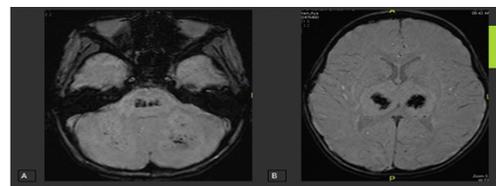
Axial Susceptibility weighted images (SWI) MRI of the brain at the level of the pons (A), Basal Ganglia and Thalami (B) Showing patchy dark blooming low signal intensity denoting parenchymal hemorrhages as well.
